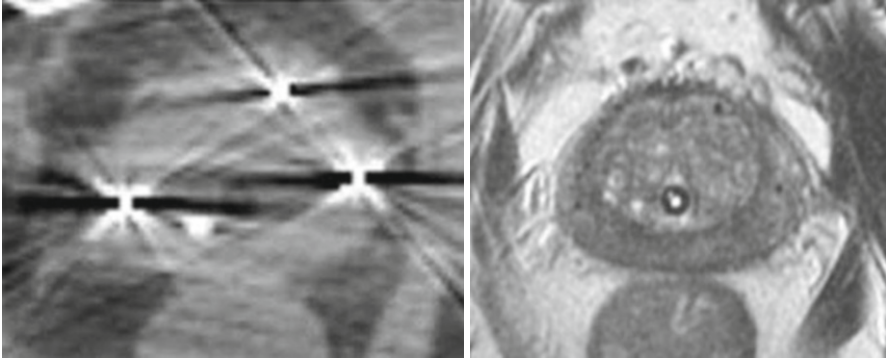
CT-based (*left panel*) versus MRI-based (*R panel*) planning images: Note “fuzzier” anatomic boundaries with surrounding tissue volume averaging, along with significant streak artifact about the fiducials on the CT-based image, with comparatively sharper anatomic prostate definition and far less prominent fiducials with no artifact on the MRI image set. Ultimately the image sets are complimentary, as CT defines tissue density most accurately for the purpose of computerized radiotherapy dose calculation, while MRI typically defines the anatomy itself most sharply for the purpose of target volume and adjacent tissues delineation
